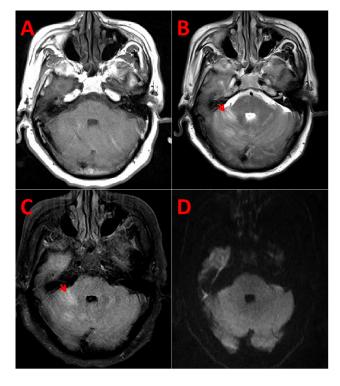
MRI results of patient 4. The MRI of the head showed high T2/Flair signals (B and C, red arrow) and normal T1/DWI signals in brachium pontis (A and D). A, T1; B,T2; C, Flair; D DWI.
